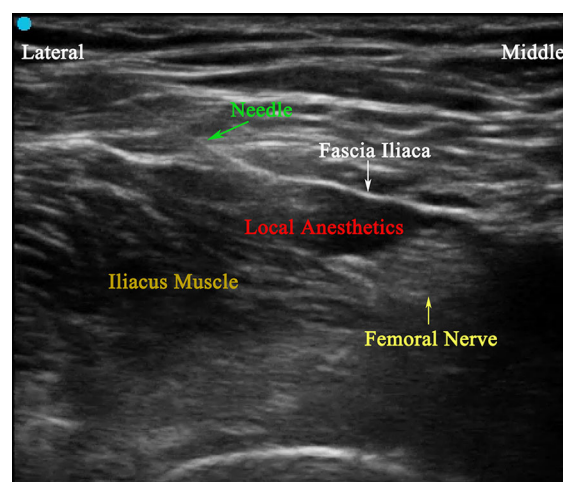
Ultrasound image of UGFICB
